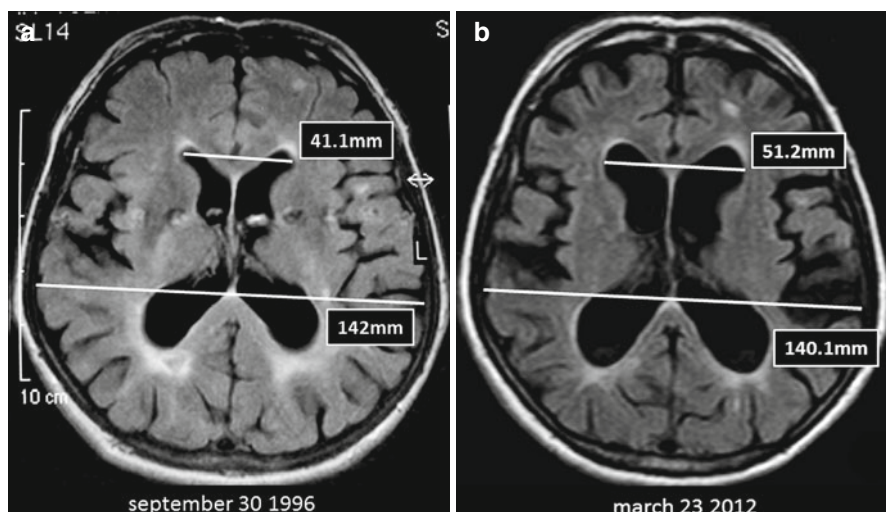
(a) A 61-year-old female with short-term memory deficit. MRI shows Evans' index of 41.1 mm/142 mm=0.28. (b) The same patient after 16 years with mild cognitive impairment, progressive gait disturbance, and occasional urinary incontinence: Evans' index of 51.2 mm/140.1 mm=0.36. Note the secondary brain atrophy with widening of the Sylvian cisterns
